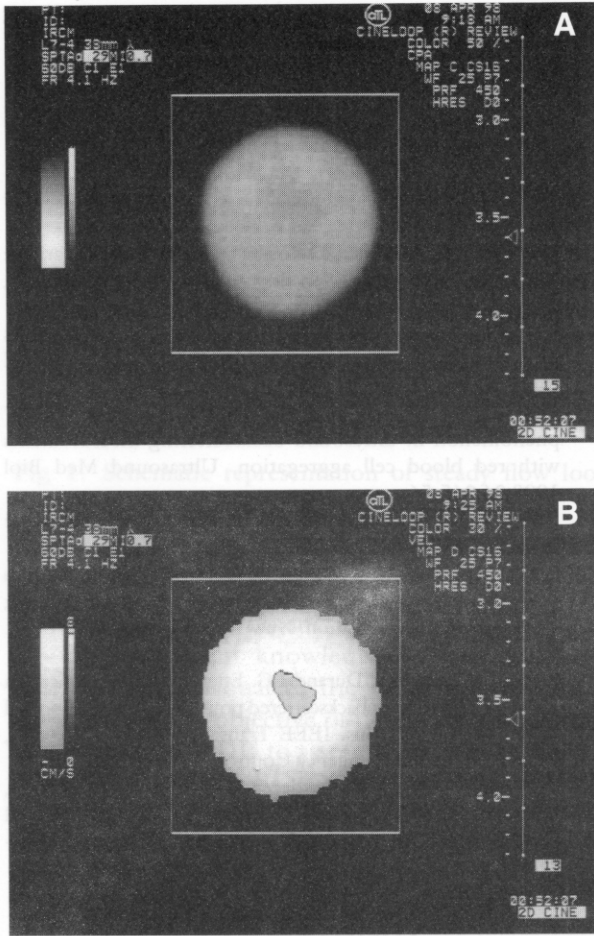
Power Doppler scan (A) and color Doppler scan flow (B) images recorded at steady flow rate of 600 mL/min and Doppler scan angle of 70 degrees. Test fluid was solution of water/glycerol (70%/30%) and 0.5 g/L of superfine Sephadex particles. PRF was set to 450 Hz to produce frequency aliasing (PRF of 600 Hz was necessary to avoid aliasing), and wall filter frequency was 25 Hz. Frequency aliasing artifact is seen on both power and color flow images.
